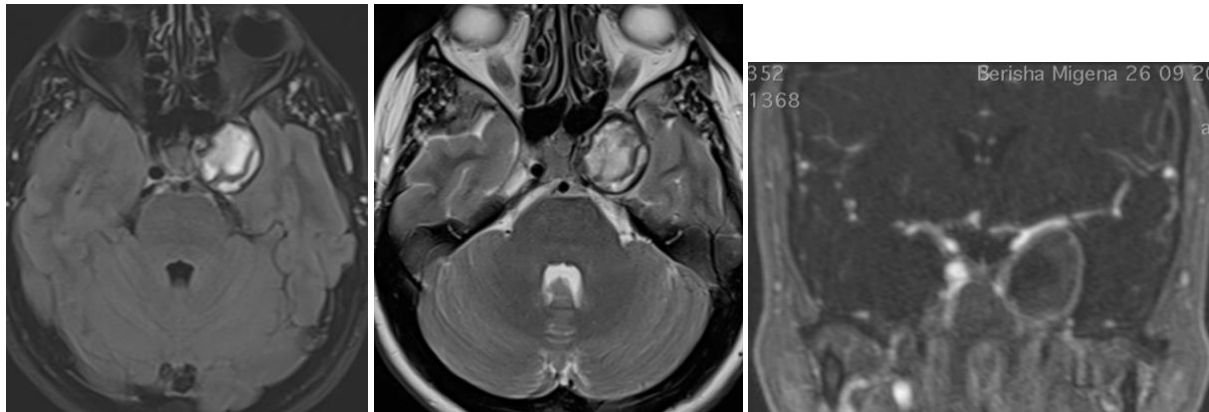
MRI showed progressive thrombosis of the aneurysm.
